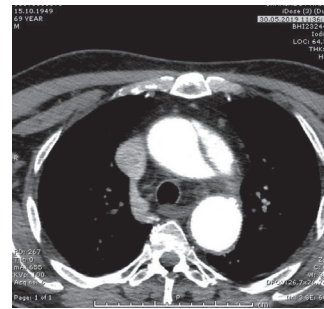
Thorax CT scan showing dissection of arcus aorta during follow up period.
